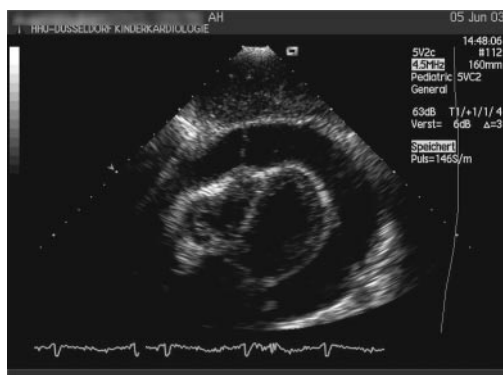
Two-dimensional echocardiogram from an apical four-chamber view shows a large pericardial effusion.
